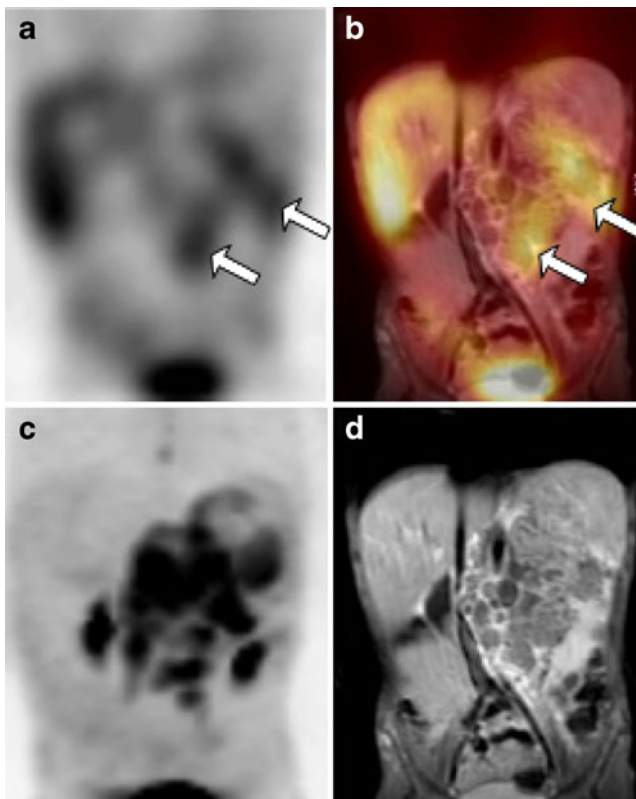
A 3½-year-old boy at primary diagnosis of a stage IV neuroblastoma and discrepant findings on ^{123}I -MIBG scan and morphological imaging. ^{123}I -MIBG scintigraphy (a SPECT, b registered SPECT/MRI) only shows a slightly increased tracer uptake at the lower and lateral border of the tumour (arrows). However, ^{18}F -FDG PET (c maximum intensity projection) and MRI (d) images demonstrate extended bulky disease and ^{18}F -FDG hypermetabolism in the entire primary tumour
